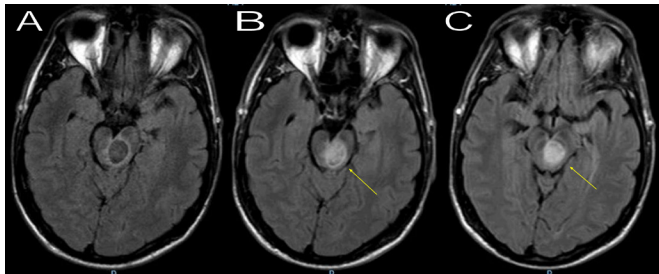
Brain MRI fluid-attenuated inversion recovery sequence. (A) Unenhanced axial view shows mild perilesional oedema, (B,C) Contrast-enhanced axial views show significant contrast enhancement (yellow arrow).
